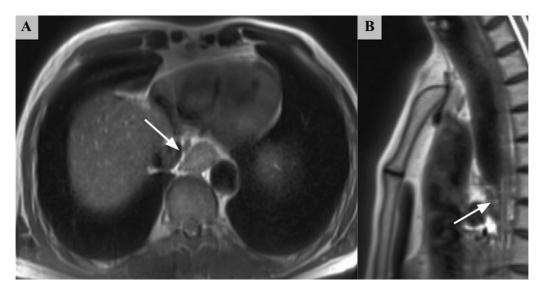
Magnetic resonance imaging (MRI) in esophageal cancer. (A and B) Axial and sagittal T2-weighted images shows heterogeneous intermediate signal intensity circumferential mural thickening involving the distal end of the esophagus (arrows).
